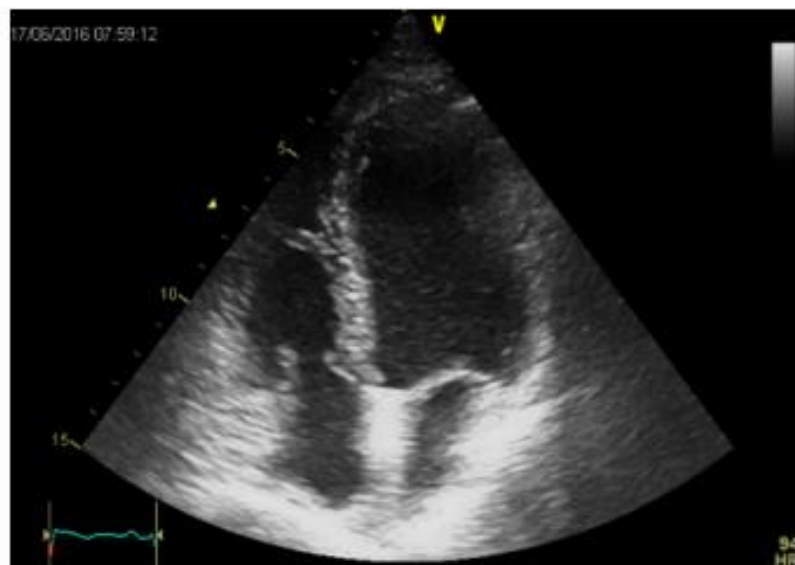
Transthoracic cardiac ultrasound at discharge – unchanged
